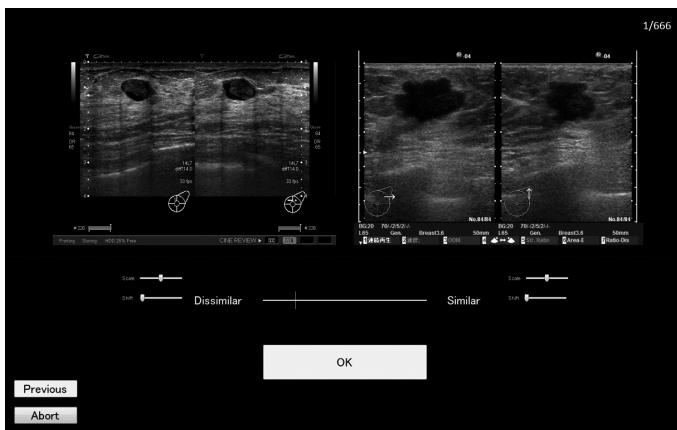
Breast ultrasound images. (a) An image of orthogonal views of a scirrhous carcinoma (invasive ductal carcinoma) and (b) an image of a single view of a ductal carcinoma in situ
